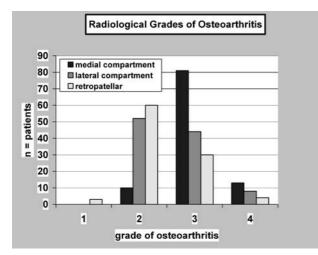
The grading of osteoarthritis was performed according to the score of Jäger and Wirth [5] on the preoperative standard weight-bearing radiographs
